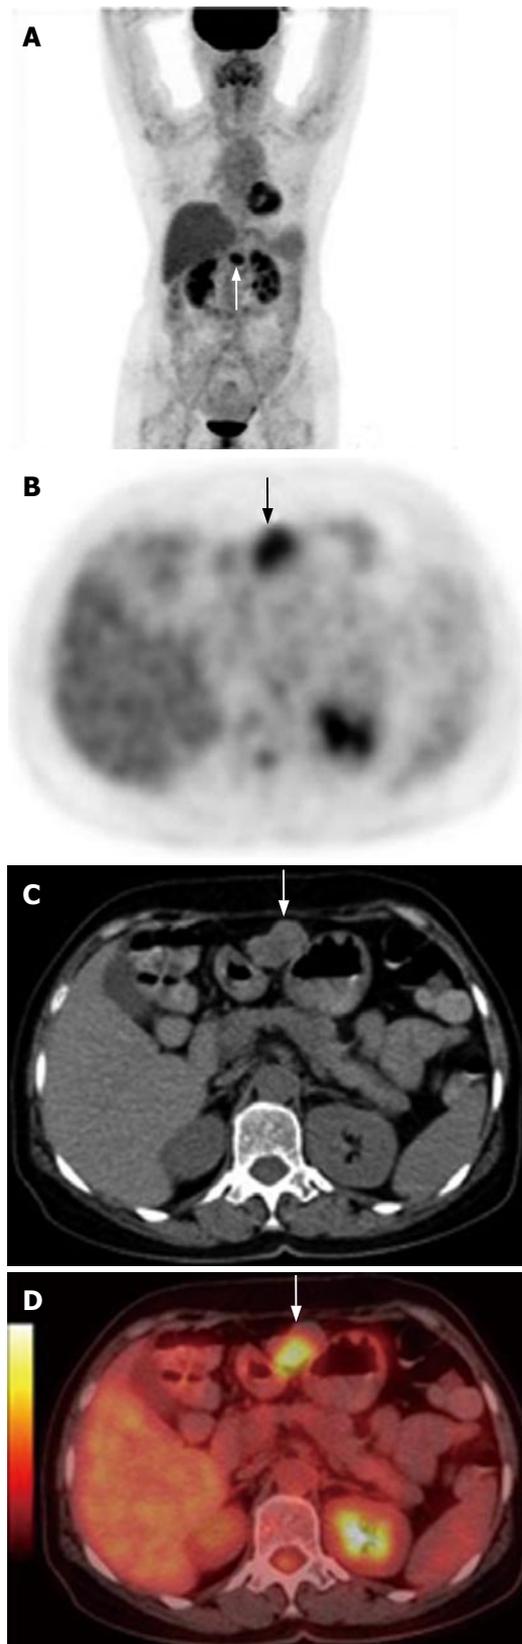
Whole body PET showing an isolated highly metabolic focus in the upper abdomen (white arrow) (A), non-enhanced CT (C) detecting a median density lesion in the omenta (white arrow), ¹⁸F-FDG PET (B) and fused imaging of PET/CT (D) revealing a highly metabolic lesion at the same position.
